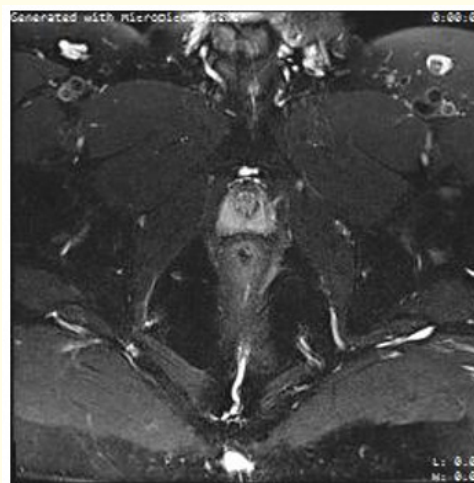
MRI 06/11/2018. A potential pilonidal sinus.
